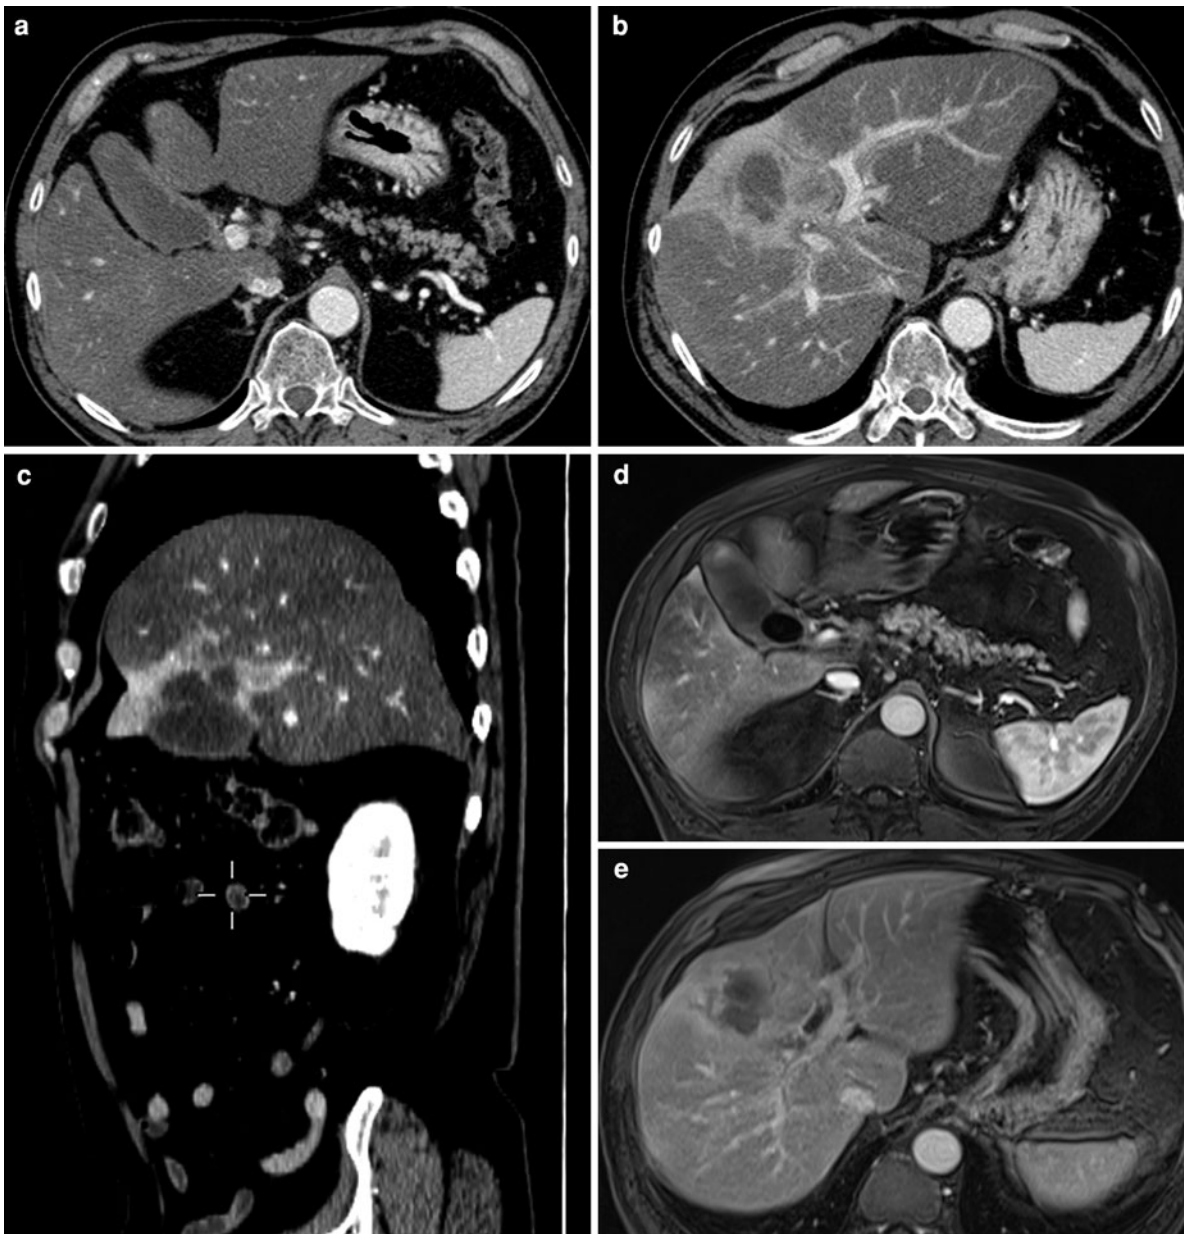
Gallbladder cancer mimicking perforated cholecystitis. A 66-year-old patient with abdominal pain and fever. CT and MRI favor the hypothesis of a calculous cholecystitis with intrahepatic abscess formation related to gallbladder wall perforation. Surgery demonstrated that it was in fact a large bulky gallbladder carcinoma, associated with inflammatory changes. Contrast-enhanced CT shows a gallbladder with an
